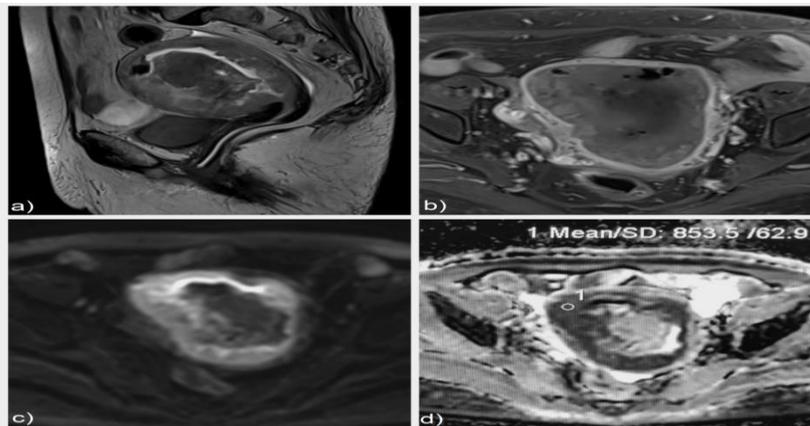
MRI pelvis showing endometrial carcinoma; a) Sagittal T2W image showing bulky uterus with irregular heterogeneously hyperintense endometrial growth along the anterior uterine wall; Few areas of signal loss are seen – calcific foci; b) axial post contrast T1FS images showing heterogeneous predominantly peripheral enhancement of the lesion. c) & d) b value and ADC images of diffusion weighted imaging, showing peripheral diffusion restriction, with corresponding low ADC value of $0.85 \times 10^{-3} \text{mm}^2/\text{s}$.
